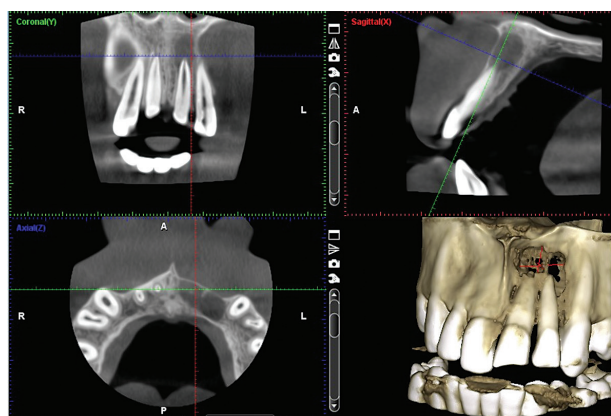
Showing pre-op CBCT image.
